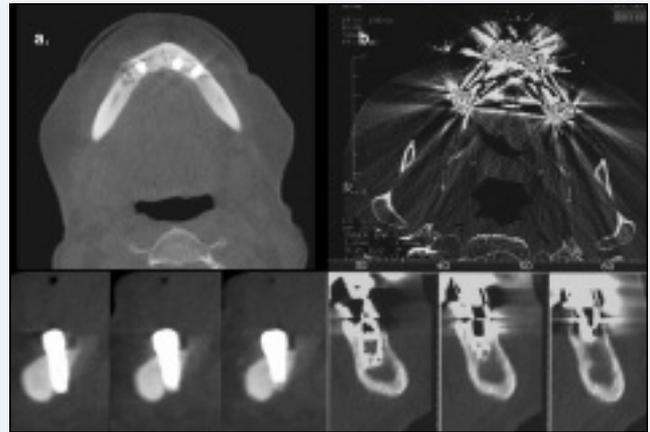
Relative image artifact reduction with CBCT (a) axial (top) and cross-sectional images (lower) of the mandibular arch with implants compared with conventional CT (b) axial (top) and cross-sectional (lower) images of maxillary arch with implants.
